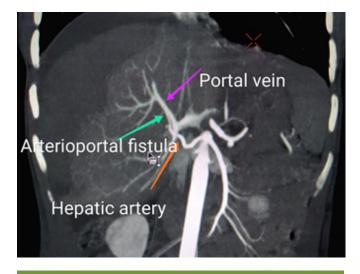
Coronal CT image arterial phase demonstrating arterioportal fistula
